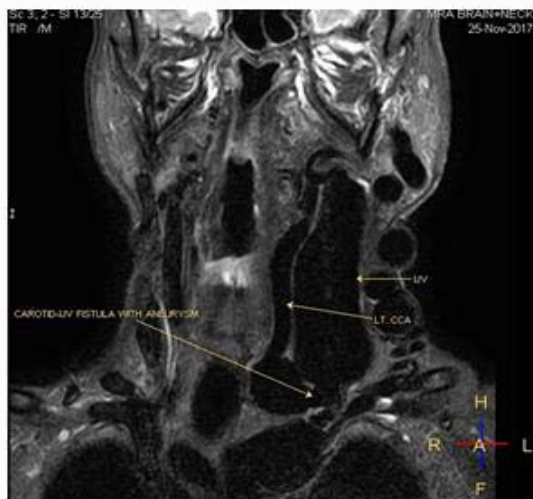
MRI Neck-Stir Long T1 image showing void of flow related signal in both left CCA and IJV.
